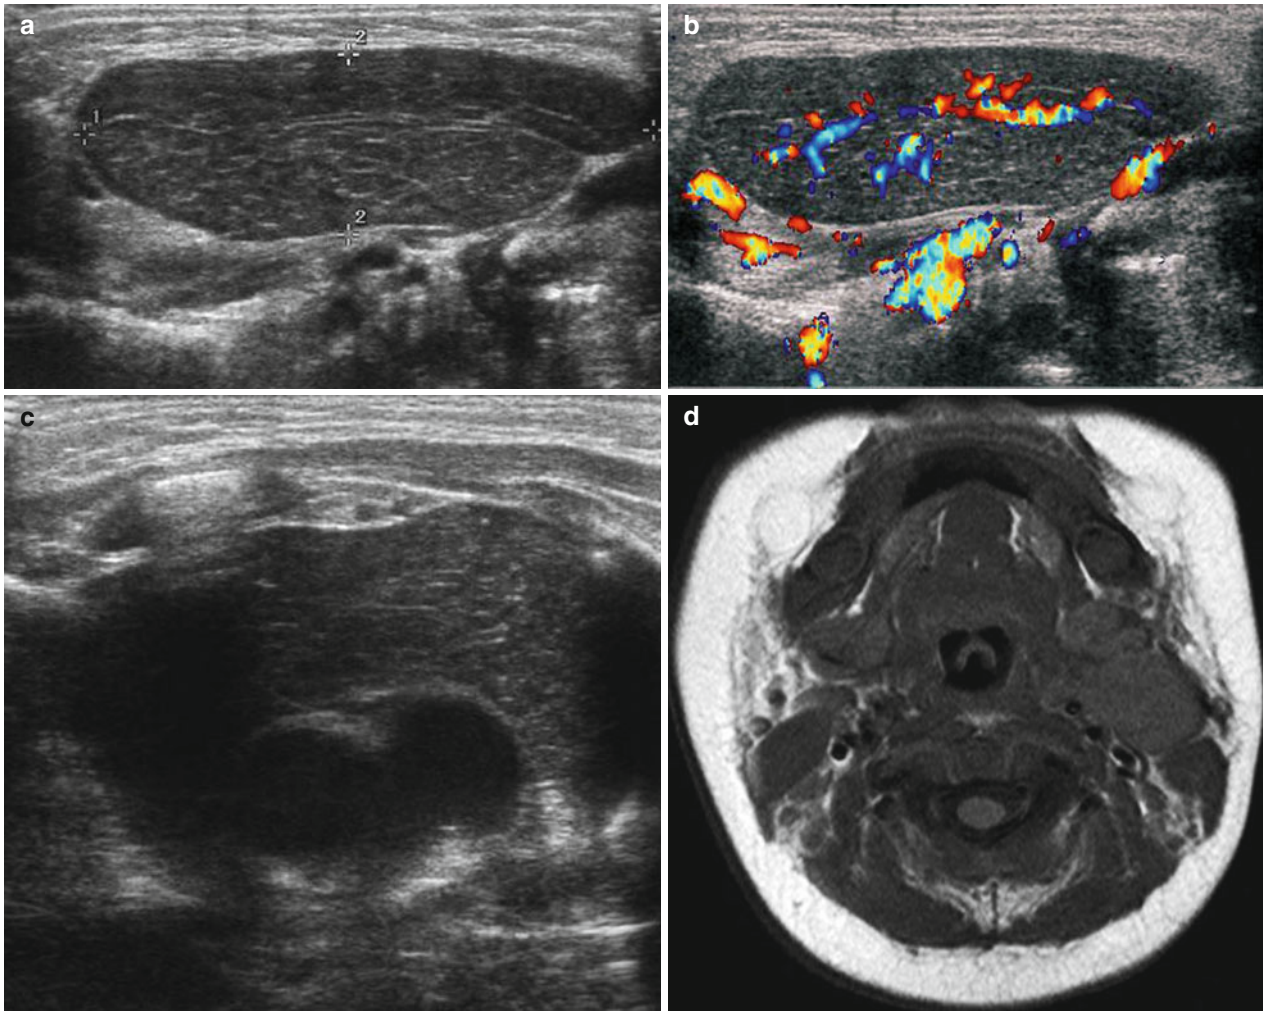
Ectopic cervical thymus in a 12-week-old infant. (a) US shows a well-defined homogeneous, hypoechoic solid mass in the left anterior deep cervical space. (b) Color Doppler US shows minimal arterial and venous flow within the mass. (c) US also shows the same natured normal thymus in the anterior mediastinum. (d, e) Axial MR images show homogeneous isosignal intensity of the mass relative to the submandibular gland and slightly high signal intensity relative to
